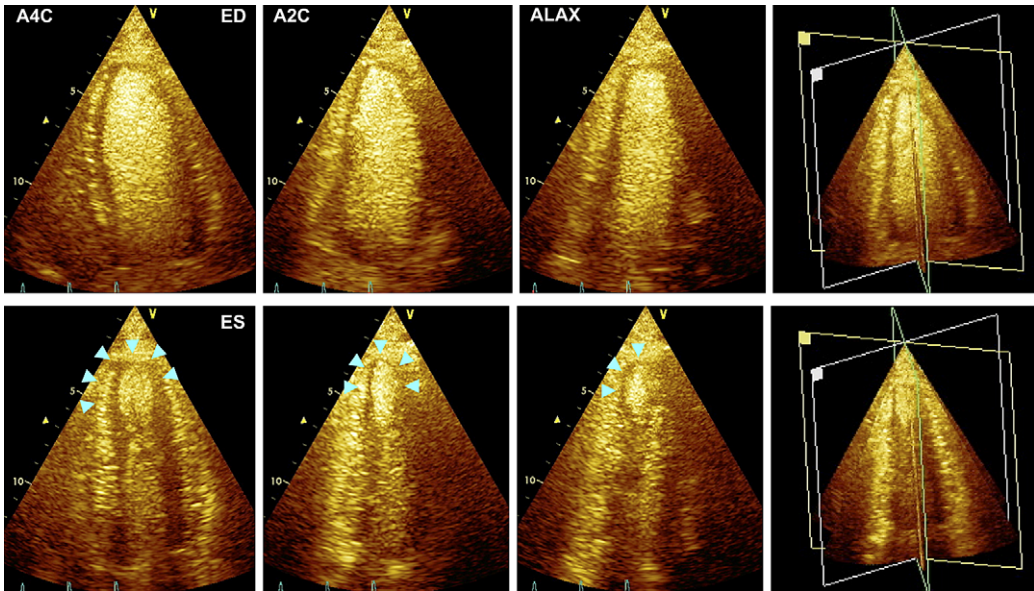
Stress-induced apical wall motion abnormalities with triplane dobutamine stress echocardiography. Real-time triplane echocardiography from the apical window allows simultaneous visualization of apical four-, two- and long-axis views. The relative angles between the three images can be adjusted. Upper panels show end-diastolic triplane images obtained at peak stress. Lower panels show end-systolic images. Apical wall motion abnormalities are shown clearly, and their extent can be evaluated.
